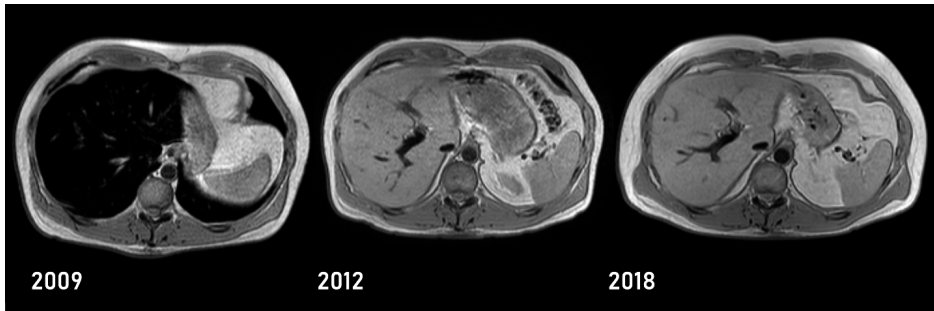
Liver MRI of case 2. The MRI in 2009 shows an important reduction in signal intensity in the liver consistent with iron accumulation. The signal intensity of the liver improves of time consistent with a significant decrease in iron deposition.
